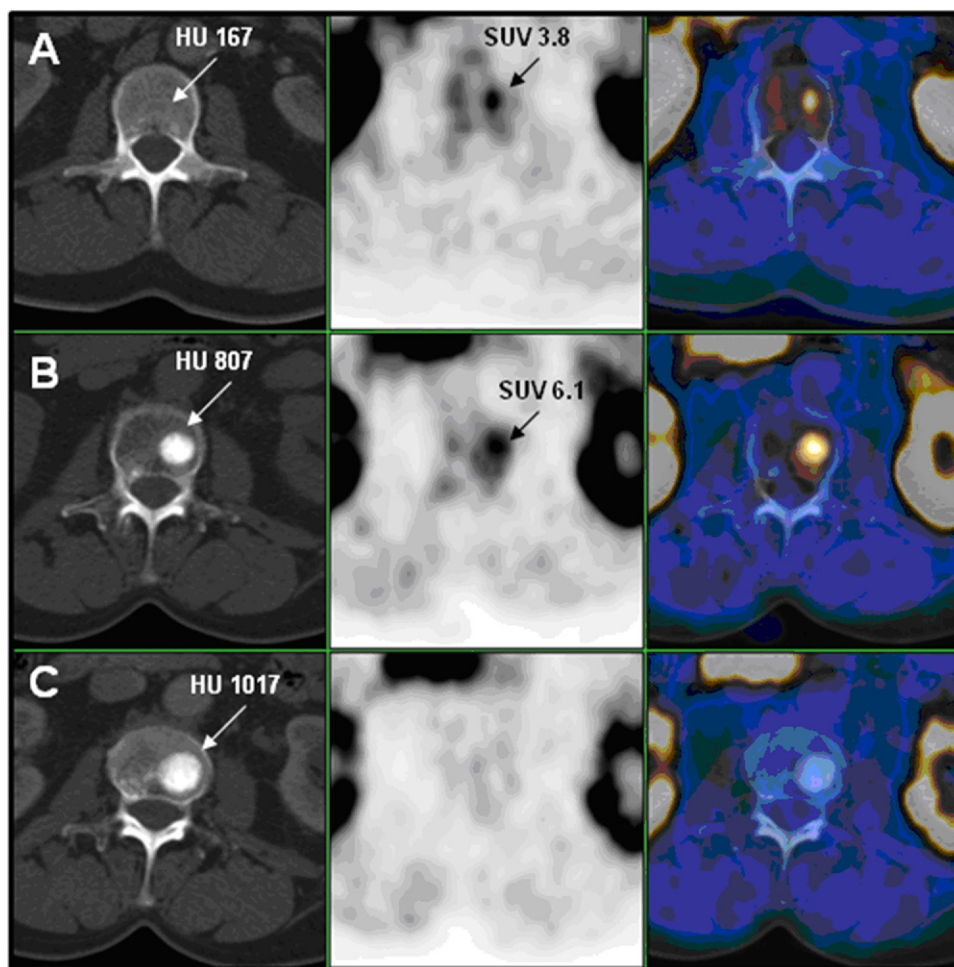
Dynamic pattern of BM detected by ^{18}F -FCH PET/CT. (A) Beginning with bone marrow involvement (FCH-positive, CT-negative), (B) then generally occurring osteoblastic changes (FCH-positive, CT-positive), and (C) finally progressing to densely sclerotic lesions without metabolic activity (FCH-negative, CT-positive). (HU: Hounsfield Unit, SUV: Standardized uptake value.)
